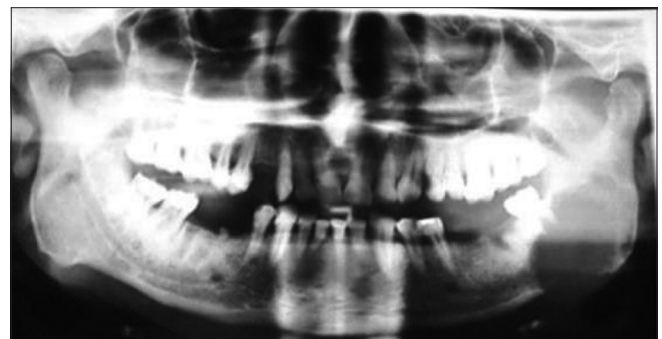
Orthopantomogram showing osteolytic lesion involving left angle and ramus of mandible
